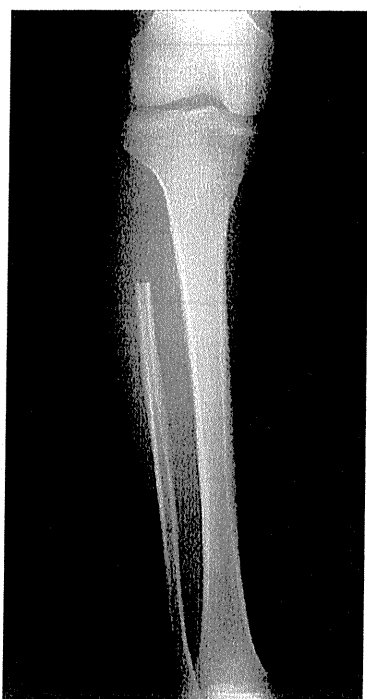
Radiograph of patient 5 obtained 1 year after the fibula head had been harvested.
